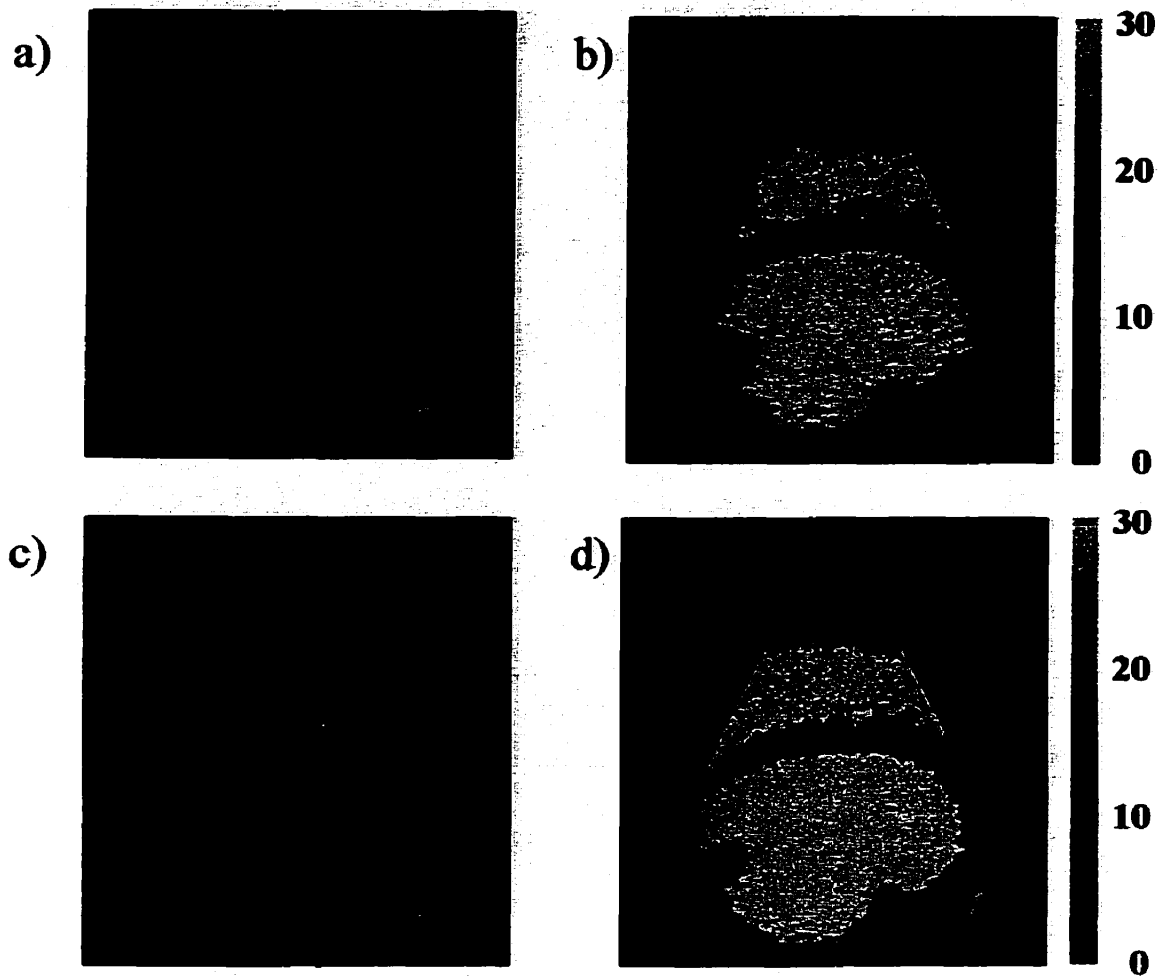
Fundamental vs Harmonic imaging: a) baseline and b) contrast enhanced harmonic PID images of heart at an MI of 1.0 made by optimizing RF and Doppler filters separately (colour dynamic range: 30 dB); c) baseline and d) contrast enhanced fundamental PID images of the heart made from the same data but using coordinated Doppler and RF filtering. In this case, fundamental imaging provided stronger and more uniform myocardial enhancement than harmonic imaging.
